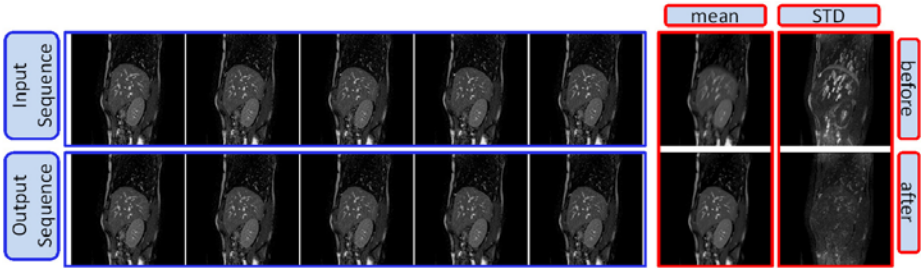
Experiment with MRI sequence. Input, output sequences and mean, STD images before and after the registration.
